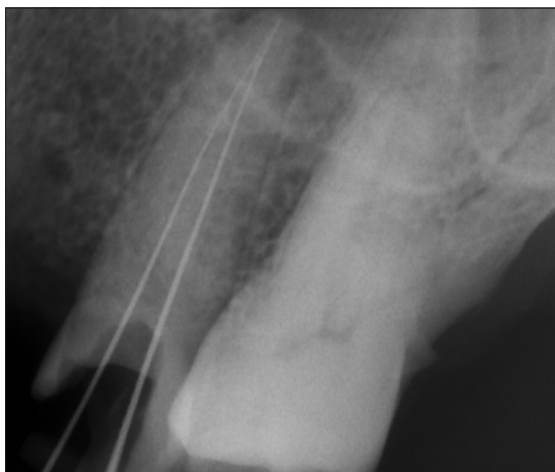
Radiograph showing the new working length
